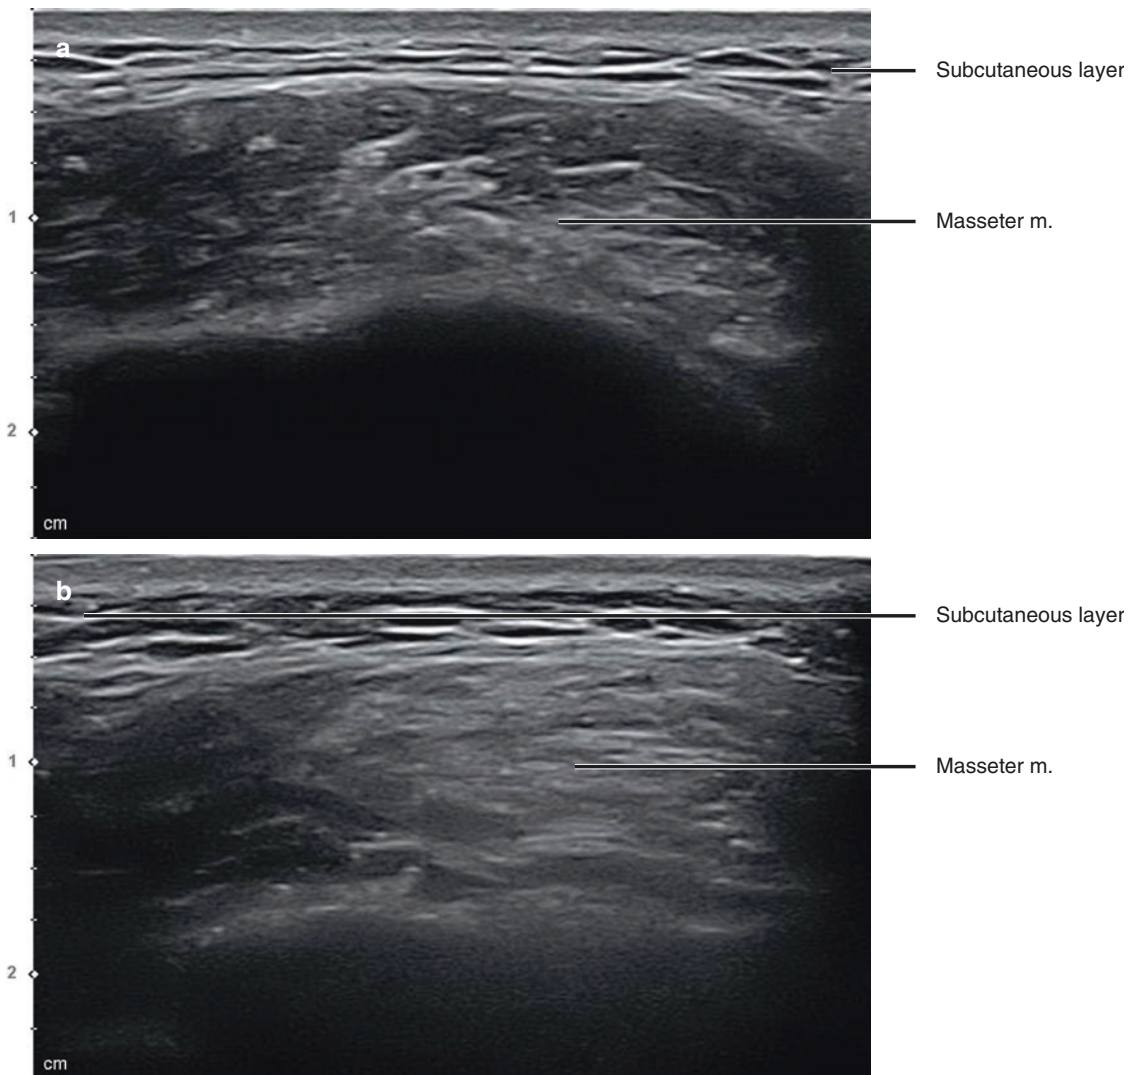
Ultrasonography of the hyperechoic change of the masseter muscle after repetitive botulinum toxin injections. (a) Partial change, B mode (transverse view, 15 MHz by linear transducer) and (b) overall change, B mode (transverse view, 15 MHz by linear transducer). (Published with kind permission of © Ji-Soo Kim 2020. All Rights Reserved)
